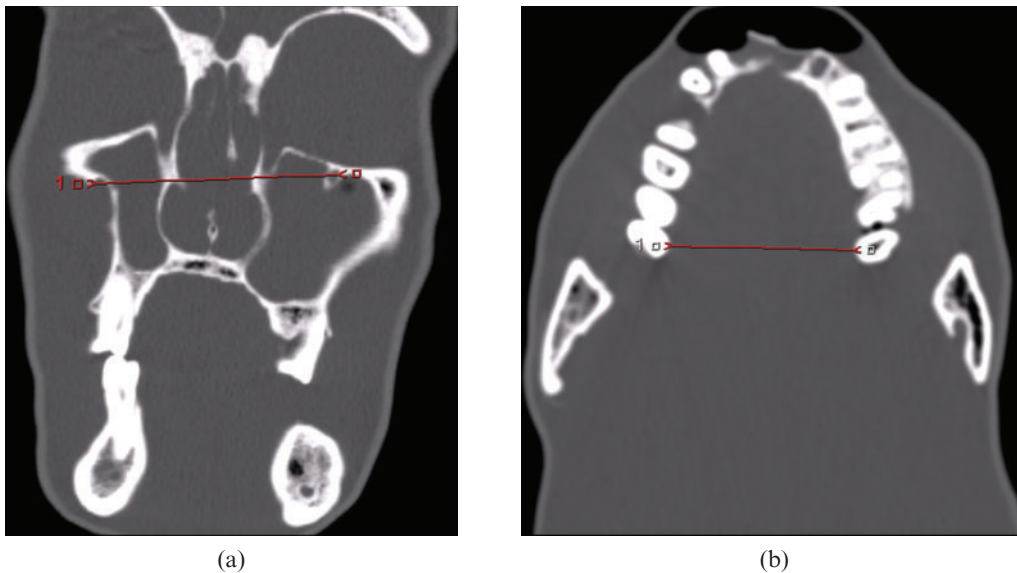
CT measurements: (a) infra-orbital foramina distance, (b) maxilla without teeth.
